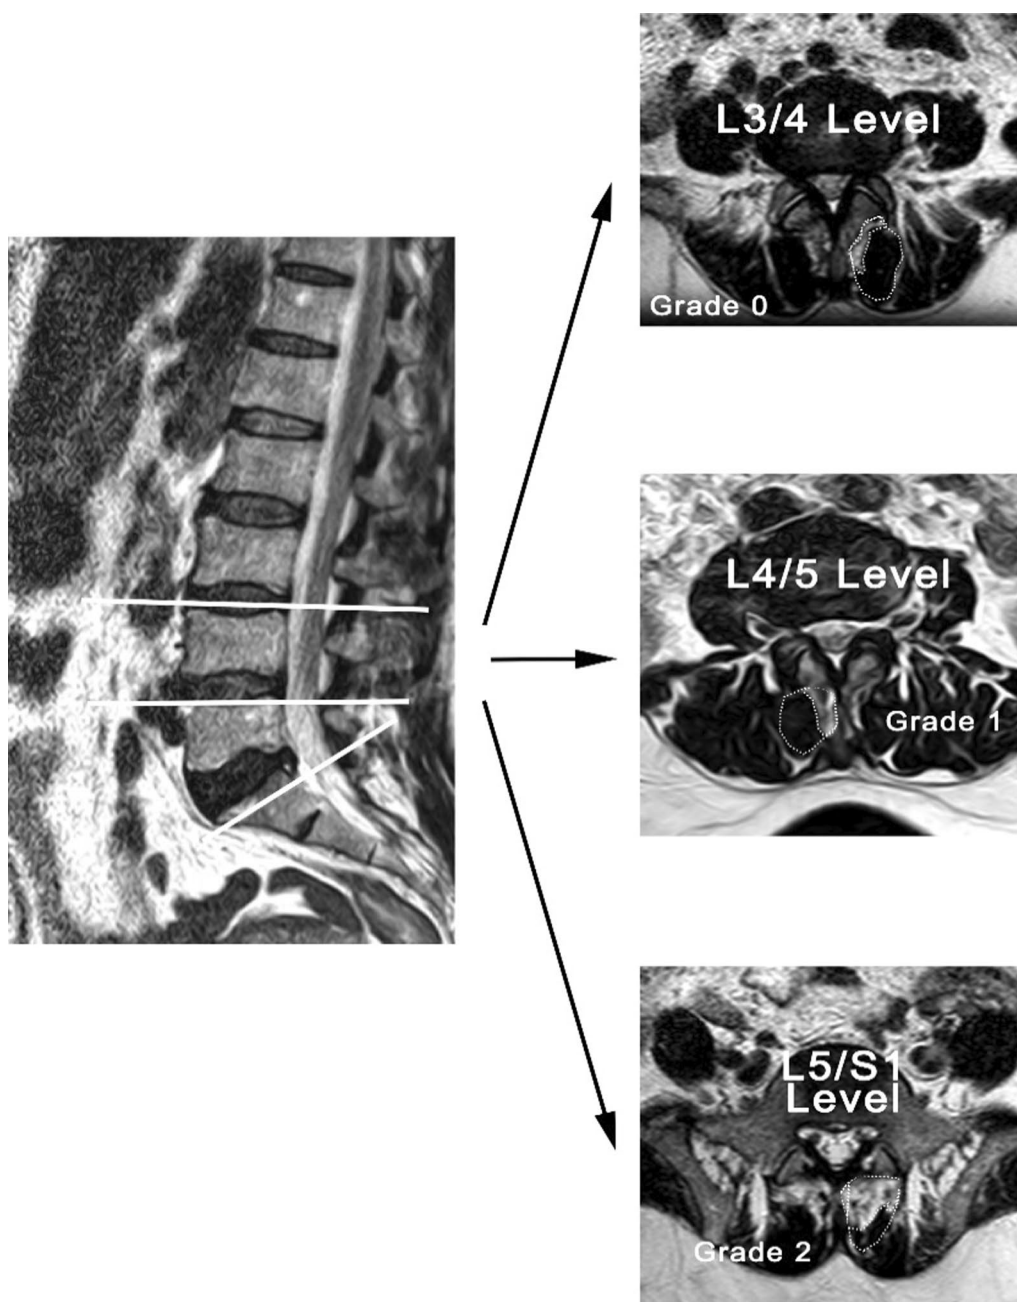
Lumbosacral MRI, of a 28-year-old man with 3 years history of LBP without sciatica, BMI = 29, there is disc bulge at L3/4 down to L5/S1 level. No neural canal stenosis. Average VAS score = 4. Axial cuts revealed grade 0 MS degeneration at L3/4 level, grade 1 MS degeneration at L4/5 level and grade 2 MS degeneration at L5/S1 level, MS = 3. $MS = 1.154 + (0.017 \times \text{Age}) + (0.184 \times \text{duration years}) + (0.081 \times \text{Sciatica}) + (0.287 \times \text{VAS})$. According to MS equation, the expected MS = 3.3
